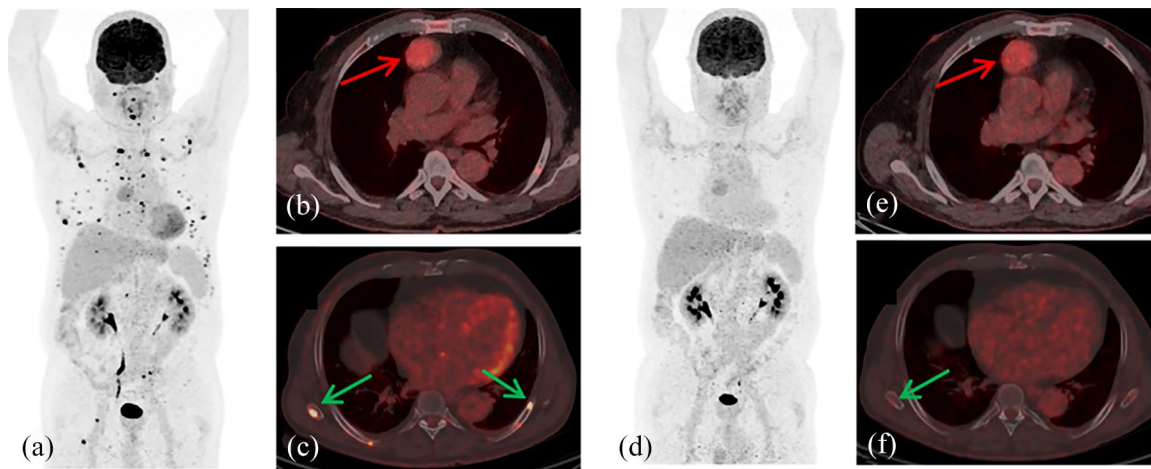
[18F]FDG-PET/CT scan series of a patient with very severe aplastic anemia and mediastinal tumor. The patient was referred for evaluation of a mediastinal mass that showed a moderate [18F]FDG uptake (SUVmax: 5.1), suspicious for thymoma (b: fused axial PET/CT slice with red arrow pointing at the mass). In addition, multiple, highly metabolic bone lesions were detected, predominantly affecting the ribs, as demonstrated on MIP-maximum intensity projection (a) and fused axial slice (c, green arrows). After withdrawal of the ongoing G-CSF therapy a second [18F]FDG-PET/CT was performed 10 days after the first scan, showing an unaltered moderate tracer accumulation in the mediastinal mass with an SUVmax of 4.6 (e: red arrow). However, the initially highly FDG-avid bone lesions almost completely resolved, with only a faint uptake left in some residual lesions (d: maximum intensity projection and f: fused axial slice; green arrow pointing at residual focal uptake in the scapula with an SUVmax decreasing from 14.7 on the first scan to 2.6). The findings are highly suggestive of a G-CSF-induced [18F]FDG accumulation in the functionally active hematopoietic bone marrow.
